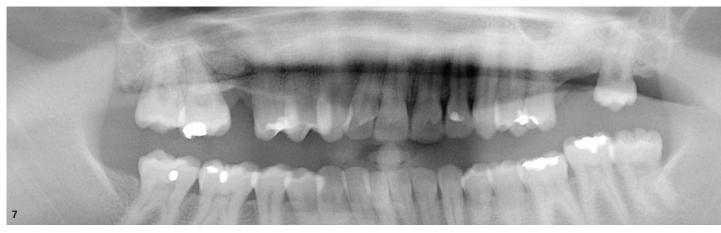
Post-augmentation X-ray imaging to verify the efficacy of the procedure.
